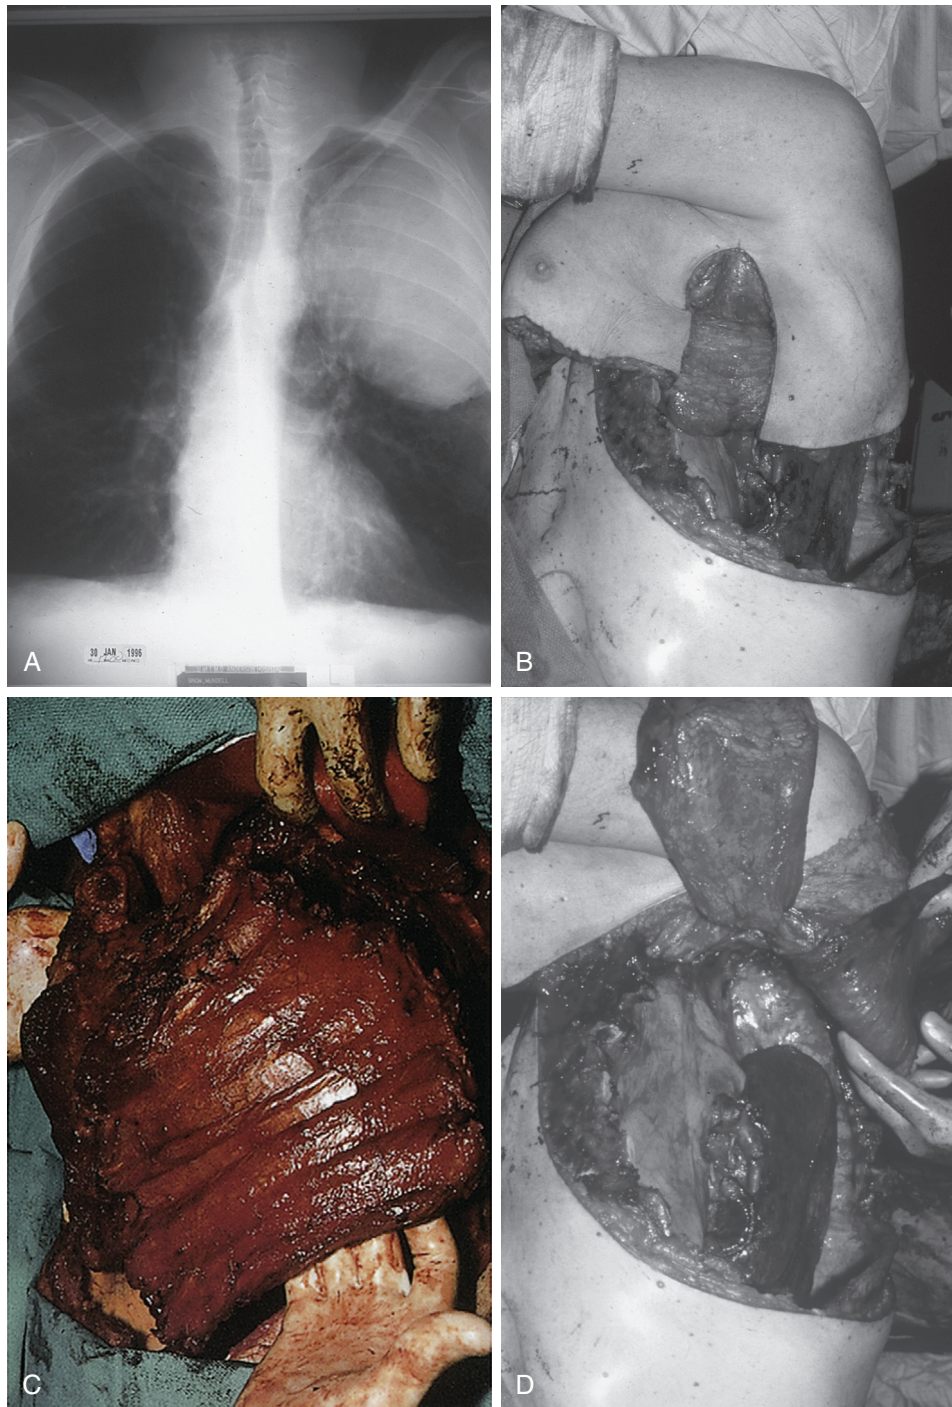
■ A, Chest radiograph posteroanterior demonstrating a large squamous cell carcinoma of the left upper lobe involving ribs one through seven. Mediastinoscopy was negative. B, Lateral operative positioning with the entail skin incision raised for muscle flaps. C, Operative photo demonstrating extensive chest wall resection of seven ribs with en bloc left upper lobe attached. D, Resulting surgical chest wall defect with previously mobilized muscle flaps (latissimus, serratus, and pectoralis) that are used to cover the prosthetic chest wall reconstruction.
